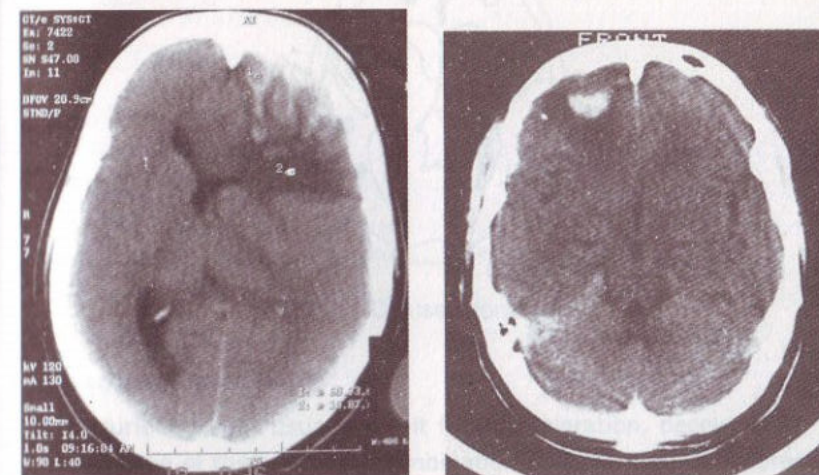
CT scan showing left frontal contusion (right) and right frontal intracerebral haematoma (left)
